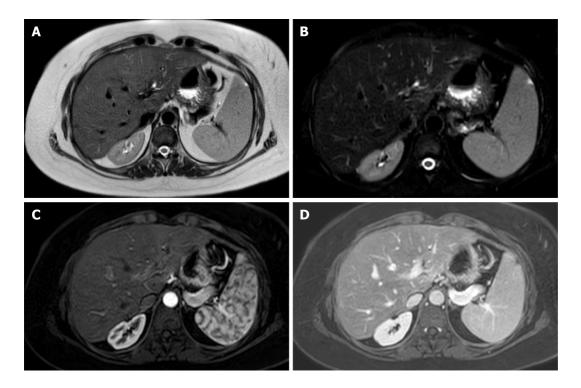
Magnetic resonance imaging of liver graft. Axial T₂-weighted single-shot fast spin-echo image. A: Fat saturation (Fat-sat); B: Contrast enhanced T₁ -weighted gradient-echo image in late arterial; C: Portal phase; D: Depicts a homogeneous signal intensity at graft parenchyma, with adequate representation of intrahepatic and extrahepatic arterial branches, venous vessels and biliary ducts, in a 32-year-old man on postoperative surveillance after a liver transplantation.
